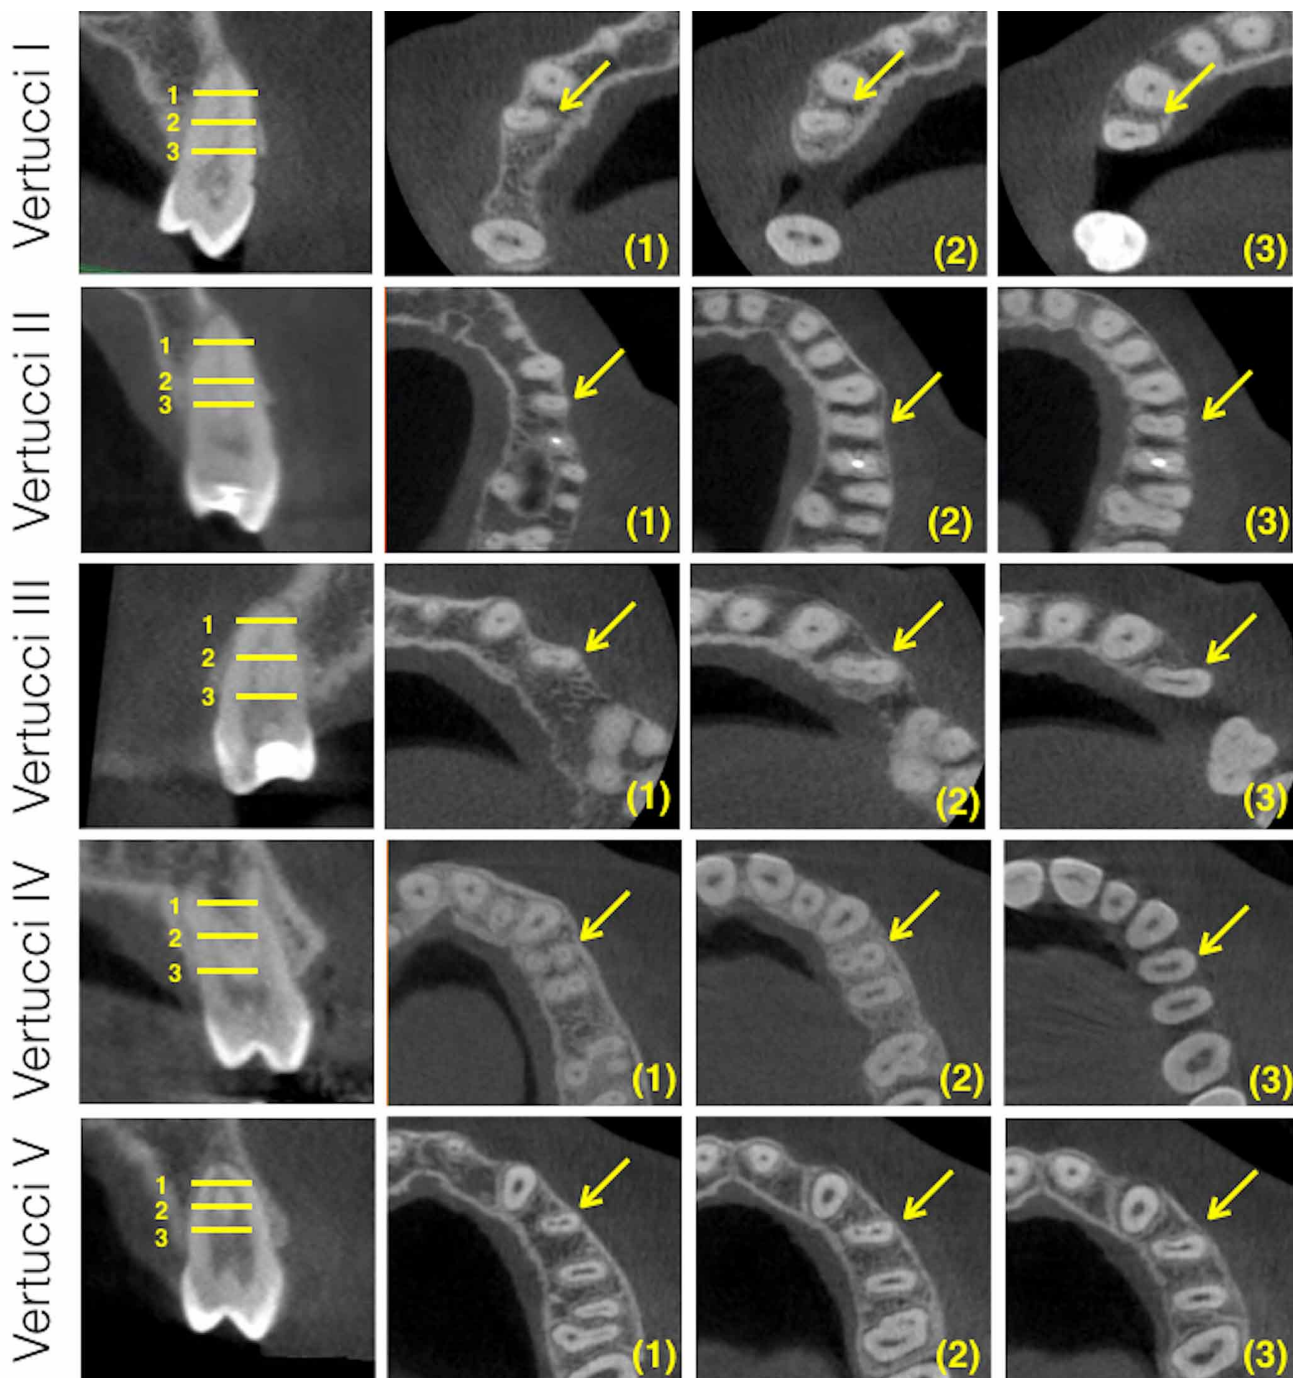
CBCT image of the morphology of the root canal system of the maxillary first premolar, following Vertucci's classification. Axial section of the tooth at 1) apical, 2) middle and 3) coronal levels. The bars indicate the root segment analysed and the yellow arrows indicate the tooth examined.
